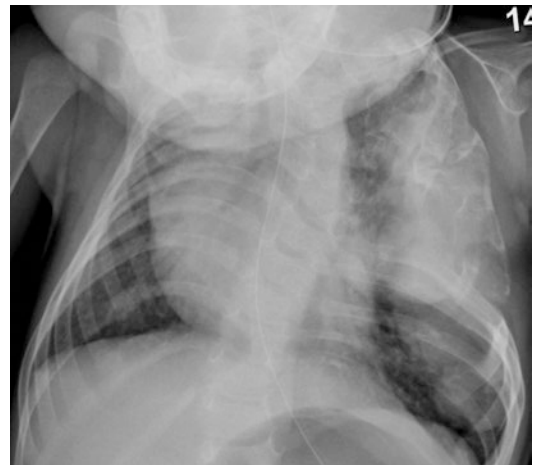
Unusual but characteristic chest radiograph appearance of a mesenchymal hamartoma
